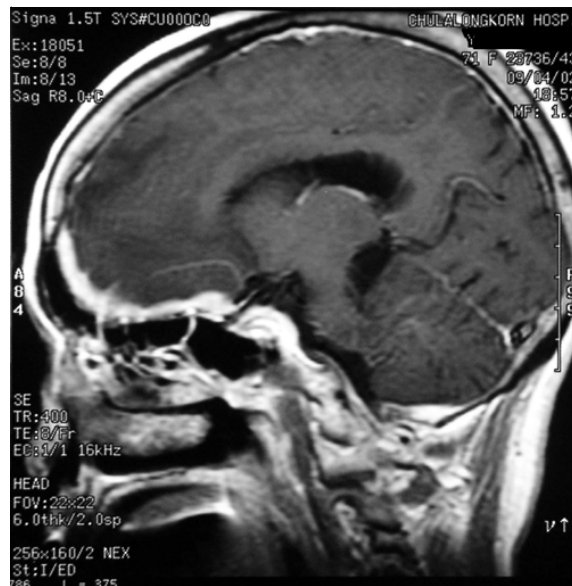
Sagittal post gadolinium MRI of the brain showed intense dural and leptomeningeal enhancement along the inferior aspect of bilateral frontal lobes with optic nerve encasement on T1WI
